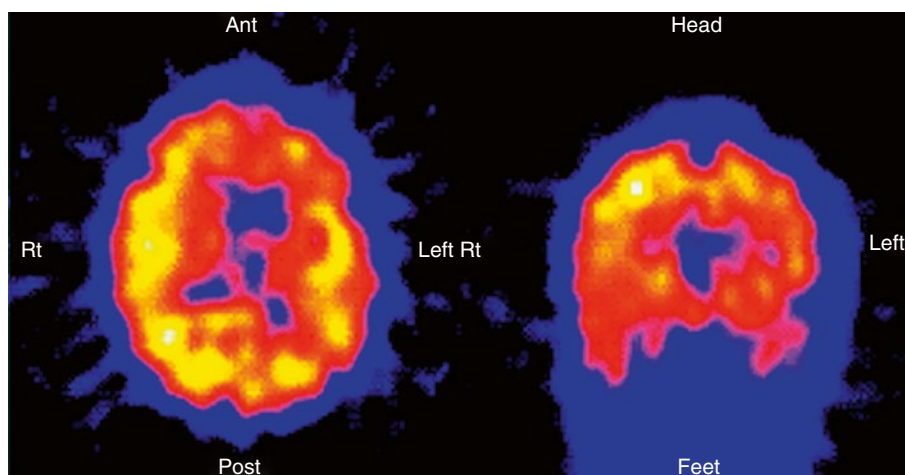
Effect of hypothermia on regional cerebral blood flow. The ^{99m}Tc -HMPAO SPECT reveals marked hypoperfusion of the left frontal, temporal, and parietal regions
